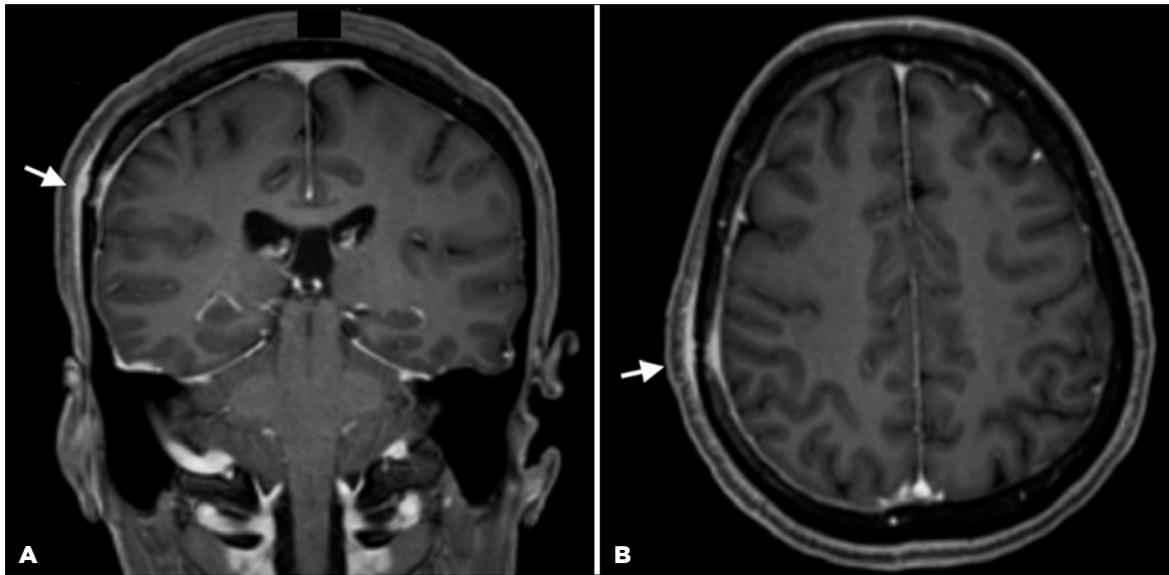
Magnetic resonance images of the (A) coronal and (B) axial frames.
